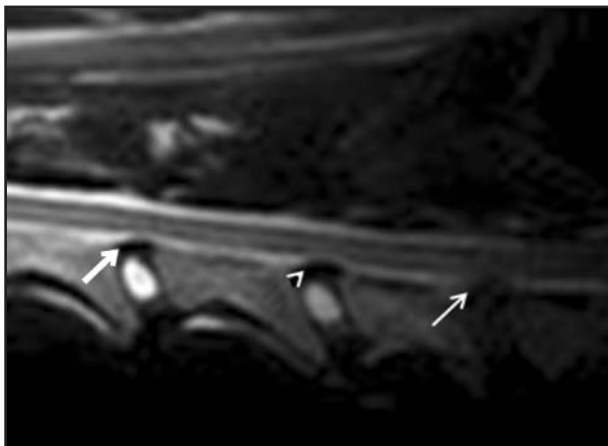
Sagittal T2-weighted image obtained during MRI of the caudal portion of the cervical vertebrae of a clinically normal Doberman Pinscher. For these 3 disk spaces, disk-associated compression was classified as partial compression of the ventral portion of the subarachnoid space (score 1 [thick arrow]), complete compression of the ventral portion of the subarachnoid space (score 2 [arrowhead]), and compression of the spinal cord (score 3 [thin arrow]).
